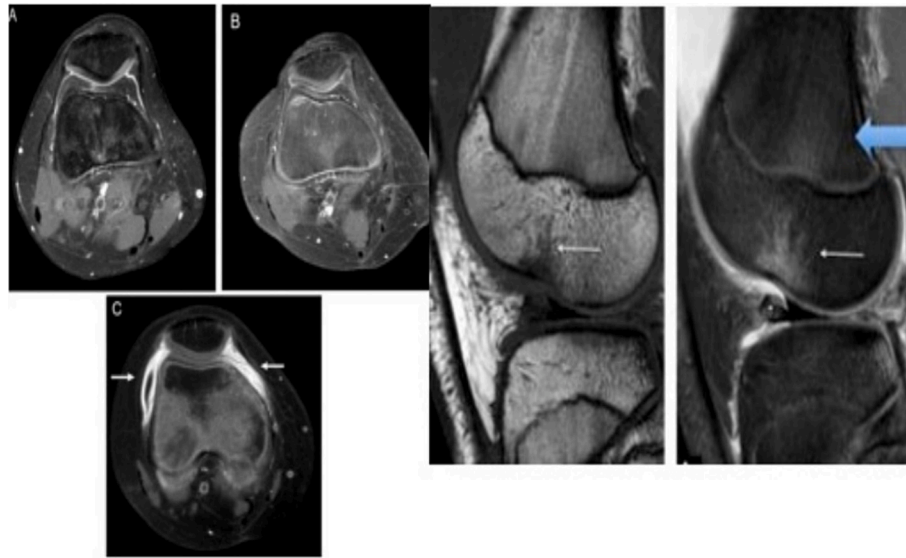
(a) Top view of the knee joint using MRI scan; (b) Kinematic analysis of the knee joint with an MRI scan.
